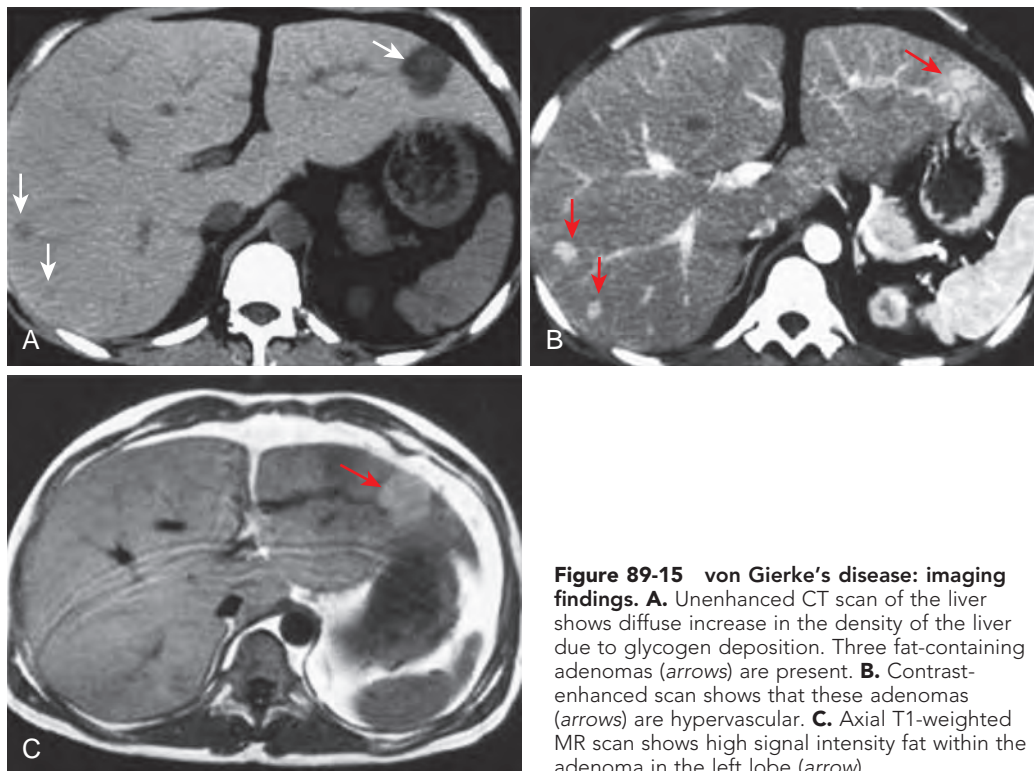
von Gierke's disease: imaging findings. A. Unenhanced CT scan of the liver shows diffuse increase in the density of the liver due to glycogen deposition. Three fat-containing adenomas (arrows) are present. B. Contrast-enhanced scan shows that these adenomas (arrows) are hypervascular. C. Axial T1-weighted MR scan shows high signal intensity fat within the adenoma in the left lobe (arrow).
